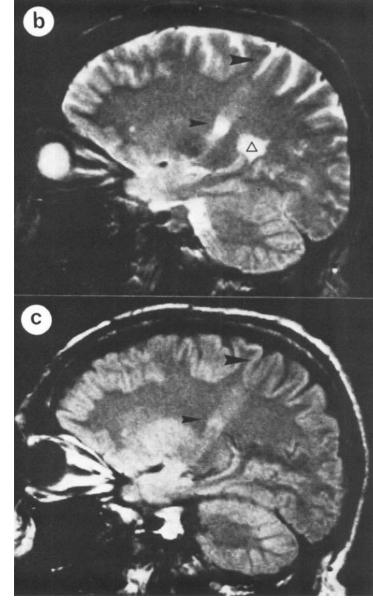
(a) Lesion site (solid black) in the dorsal part of the posterior limb of the internal capsule according to cranial computed tomography (horizontal scan) of a 51-year-old male who 4 months before the CCT had suddenly developed a right-sided ataxic hemiparesis.
